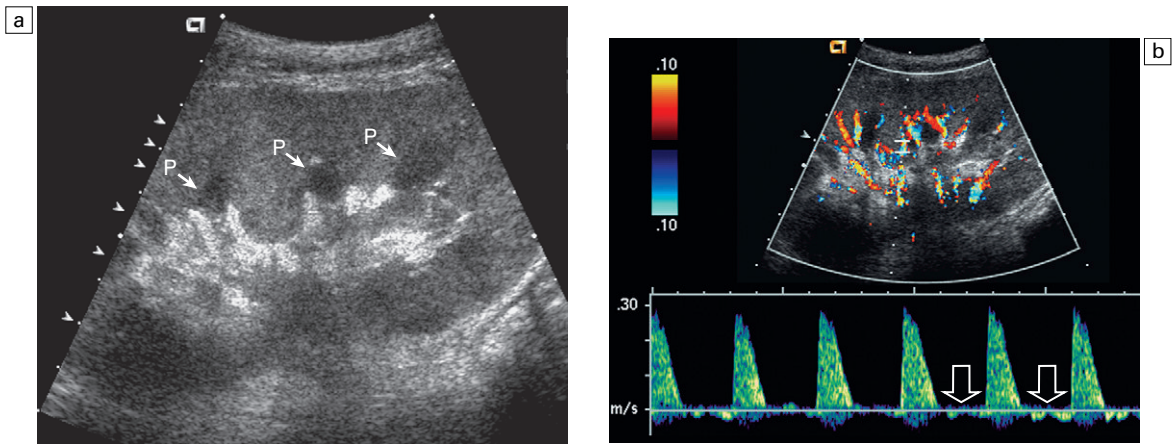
(a) Longitudinal grey-scale image obtained with 24 h of implantation. This cadaver organ experienced prolonged ischaemic time. Note that the kidney is not particularly rounded and the sinus fat is preserved. The medullary pyramids (P), however, are prominent, hypoechoic and oedematous. (b) Spectral and colour Doppler image of the same kidney. The resistive index is elevated to over 100% since reversed flow can be perceived in diastole (arrows). This combination of findings in the appropriate clinical situation is consistent with acute tubular necrosis. This can be seen in the immediate post-operative state but can also be caused by drug toxicity.
